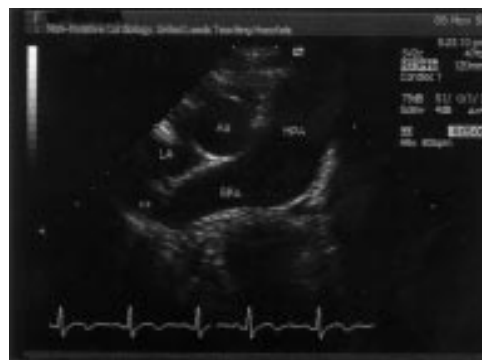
Transoesophageal echocardiogram. Ao, aorta; LA, left atrium; MPA, main pulmonary artery; RPA, right pulmonary artery.
